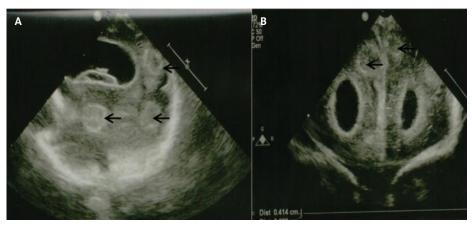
Cranial ultrasound images at 30 days of life before commencing antifungal treatments. (A) Right lateral (sagittal) view. The arrows indicate brain abscesses in the parietal, occipital and temporal areas of the brain. (B) Frontal (coronal) view at the level of the anterior horns of the lateral ventricles. The arrows indicate brain abscesses on either side of the midline.
